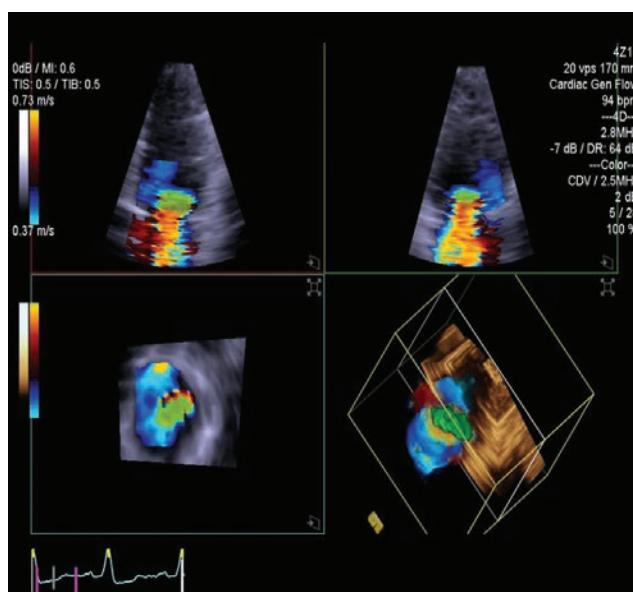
3D transthoracic echocardiography – semiautomatic recognition of 3D PISA volume in mitral regurgitation.
